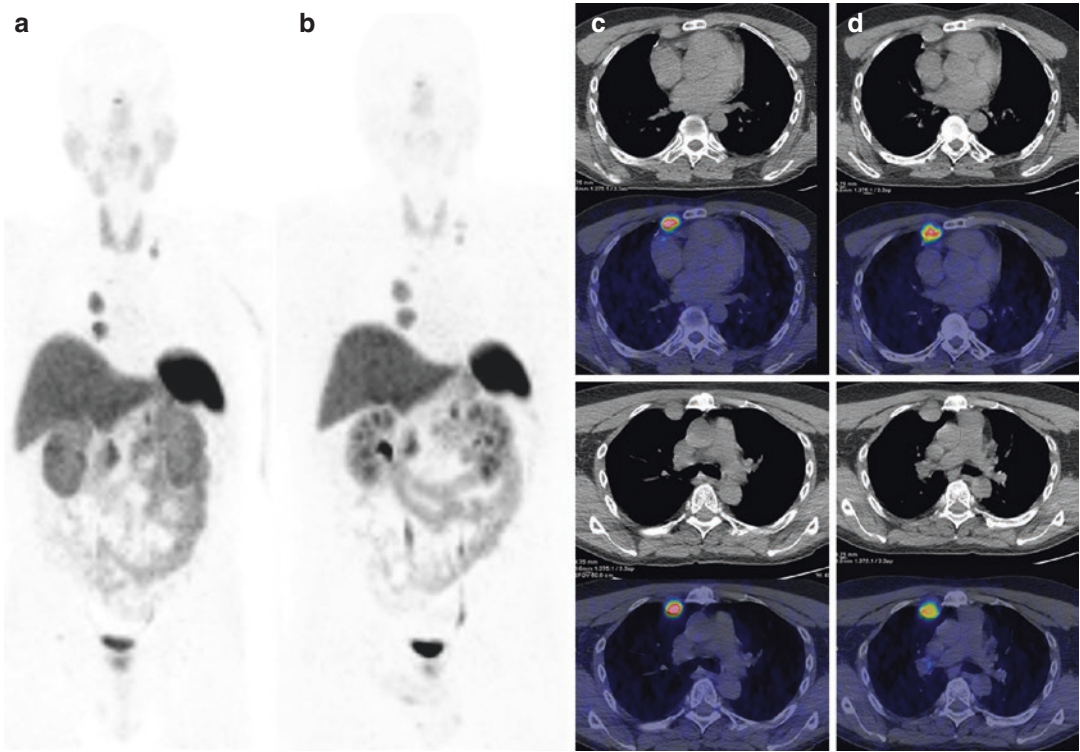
Neuroendocrine tumor of the thymus. ^{68}Ga -DOTATOC PET/CT at baseline (a, c) demonstrated multiple sites of pathological uptake in lymph nodes. The patient underwent five cycles of $^{177}\text{Lu}/^{90\text{Y}}$ -DOTATOC
